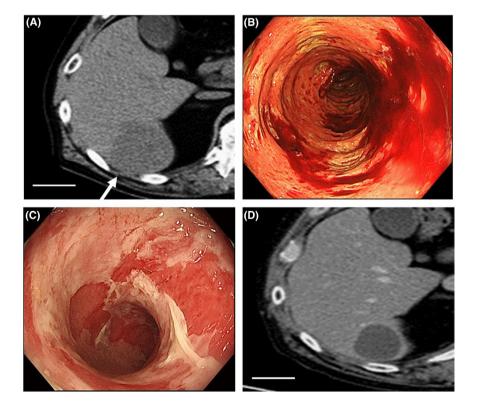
A, Computed tomography detected a growing metastatic lesion in S6 of the liver (arrow). Scale bar indicates 5 cm. B, Endoscopic observation showed multiple mucosal ulcers and bleeding. C, White re-epithelization was noticed after the administration of three doses of infliximab. D, The lesion shown in A shrank was well defined. Scale bar indicates 5 cm
